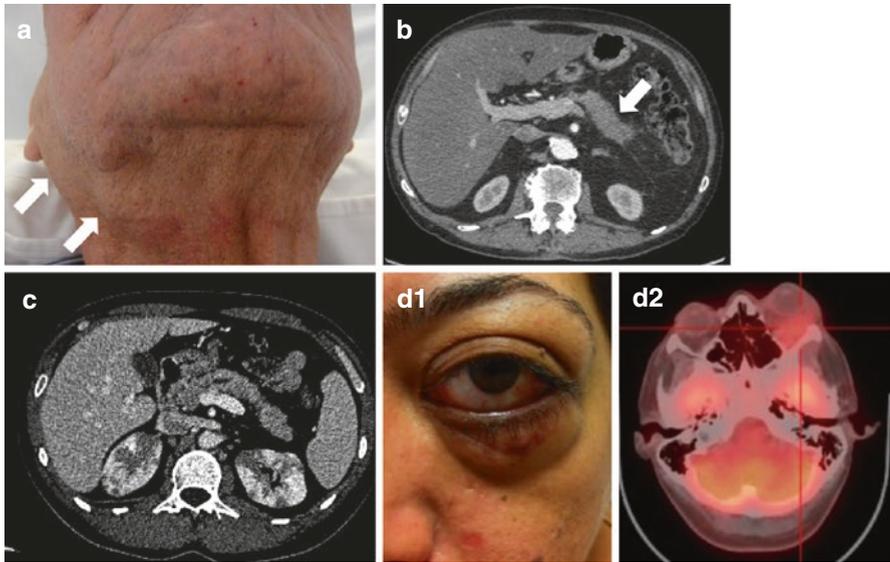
(a) Parotid and submandibular gland involvement by IgG4-related disease. The *arrows* show the parotid and the submandibular enlargement in an 82-year-old man. (b) Abdominal CT scan showing an atypical caudal pancreatic enlargement (*arrow*) revealing IgG4-related pancreatitis. (c) CT scan showing bilateral pseudotumoral kidney masses revealing IgG4-related kidney involvement. (d1, d2) Unilateral exophthalmos with an orbital mass seen on PET (d2) revealing an IgG4-related orbitopathy
